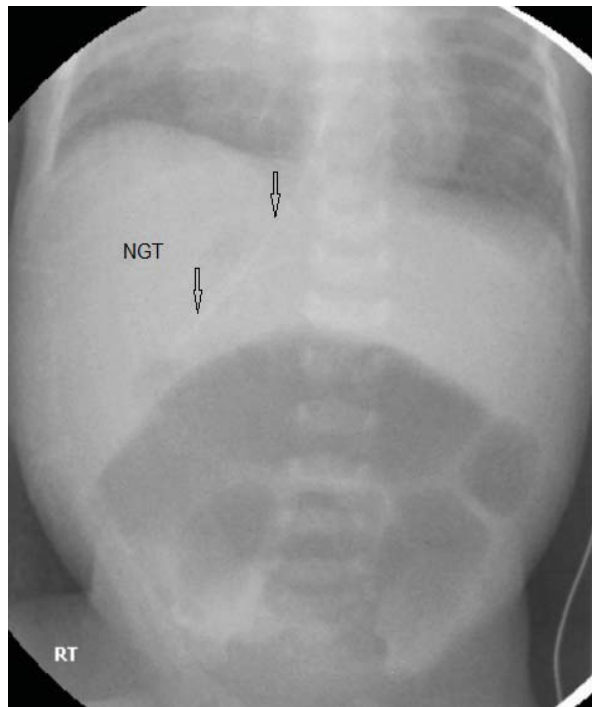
Abdominal X-ray showed that the NGT is passing to the right side with significantly dilated proximal small bowel loops and normal cardiac and hepatic shadows.
